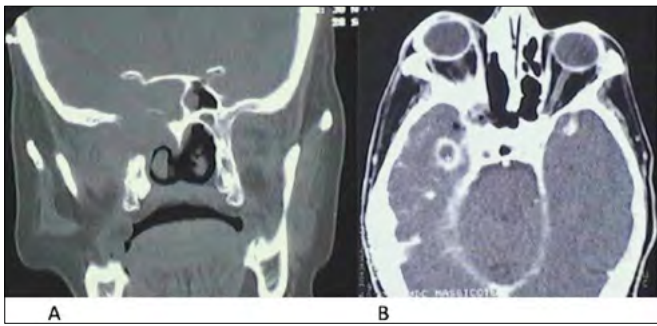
(A) CT with pathological tissue in the nasopharynx with invasion of skull base; (B) CT with contrast enhancement revealed a right brain abscess.
